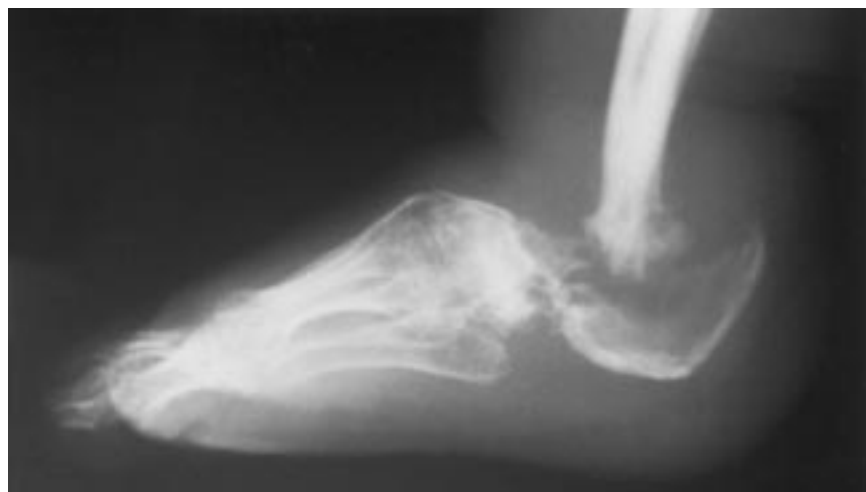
Lateral radiograph of the foot of a patient with insulin-dependent diabetes mellitus shows complete dissolution of the talus and most of the distal tibia and calcaneus.
